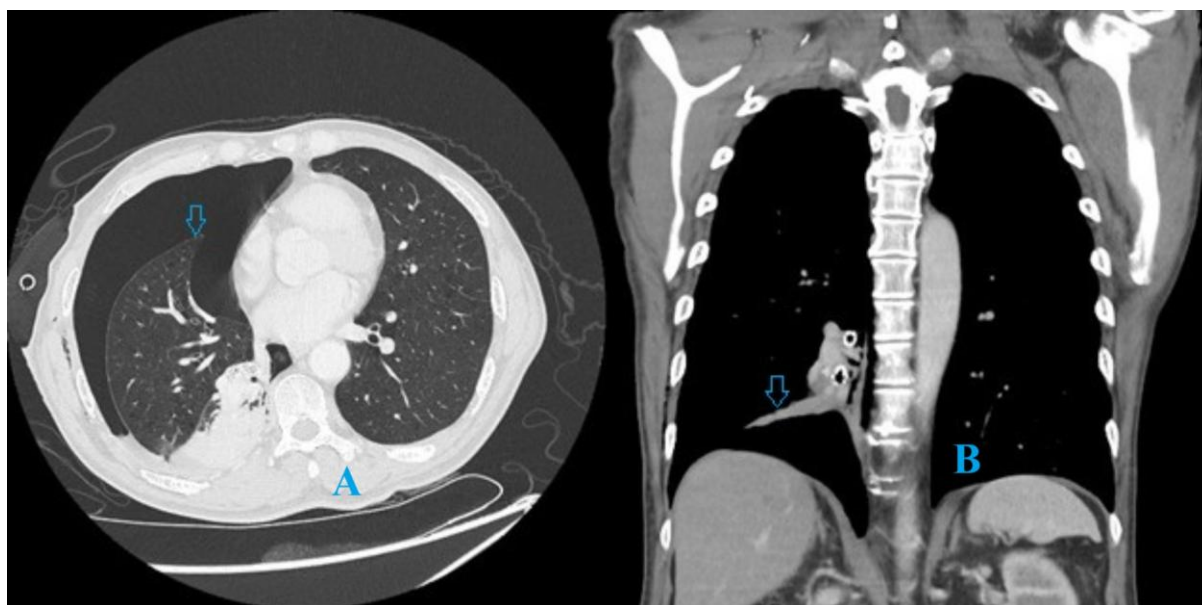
(A & B): CT images post first EBV insertion into the right lower lobe demonstrated persistent air leak and collapsed right lung (Arrow).
